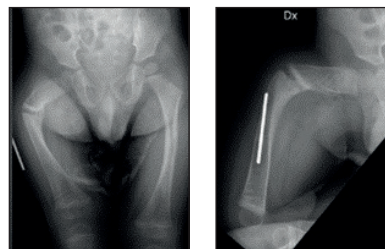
AP and lateral Radiographs of the femurs of patient at 2 years old
